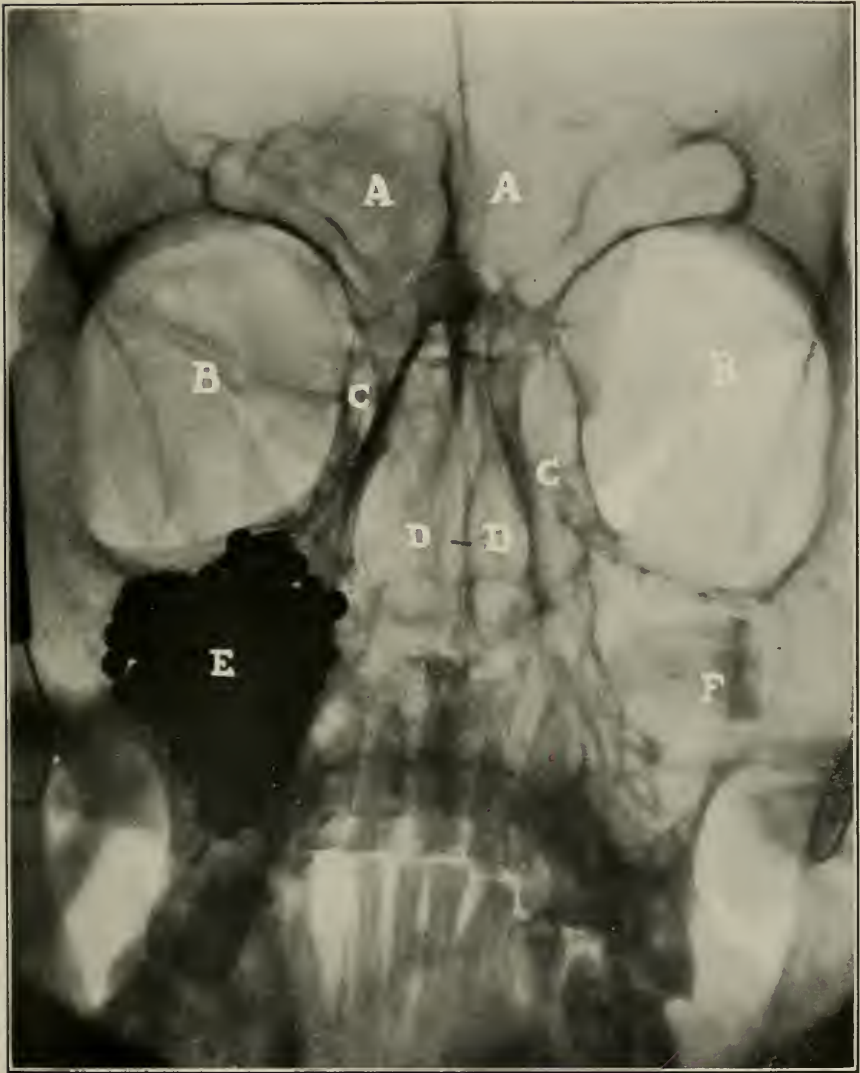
Radiograph of a dry skull. One antrum is filled with lead shot, the other has a molar tooth in it. This radiograph is clearer than one made from the living subject because there were no soft parts or circulating blood to blot out detail.
